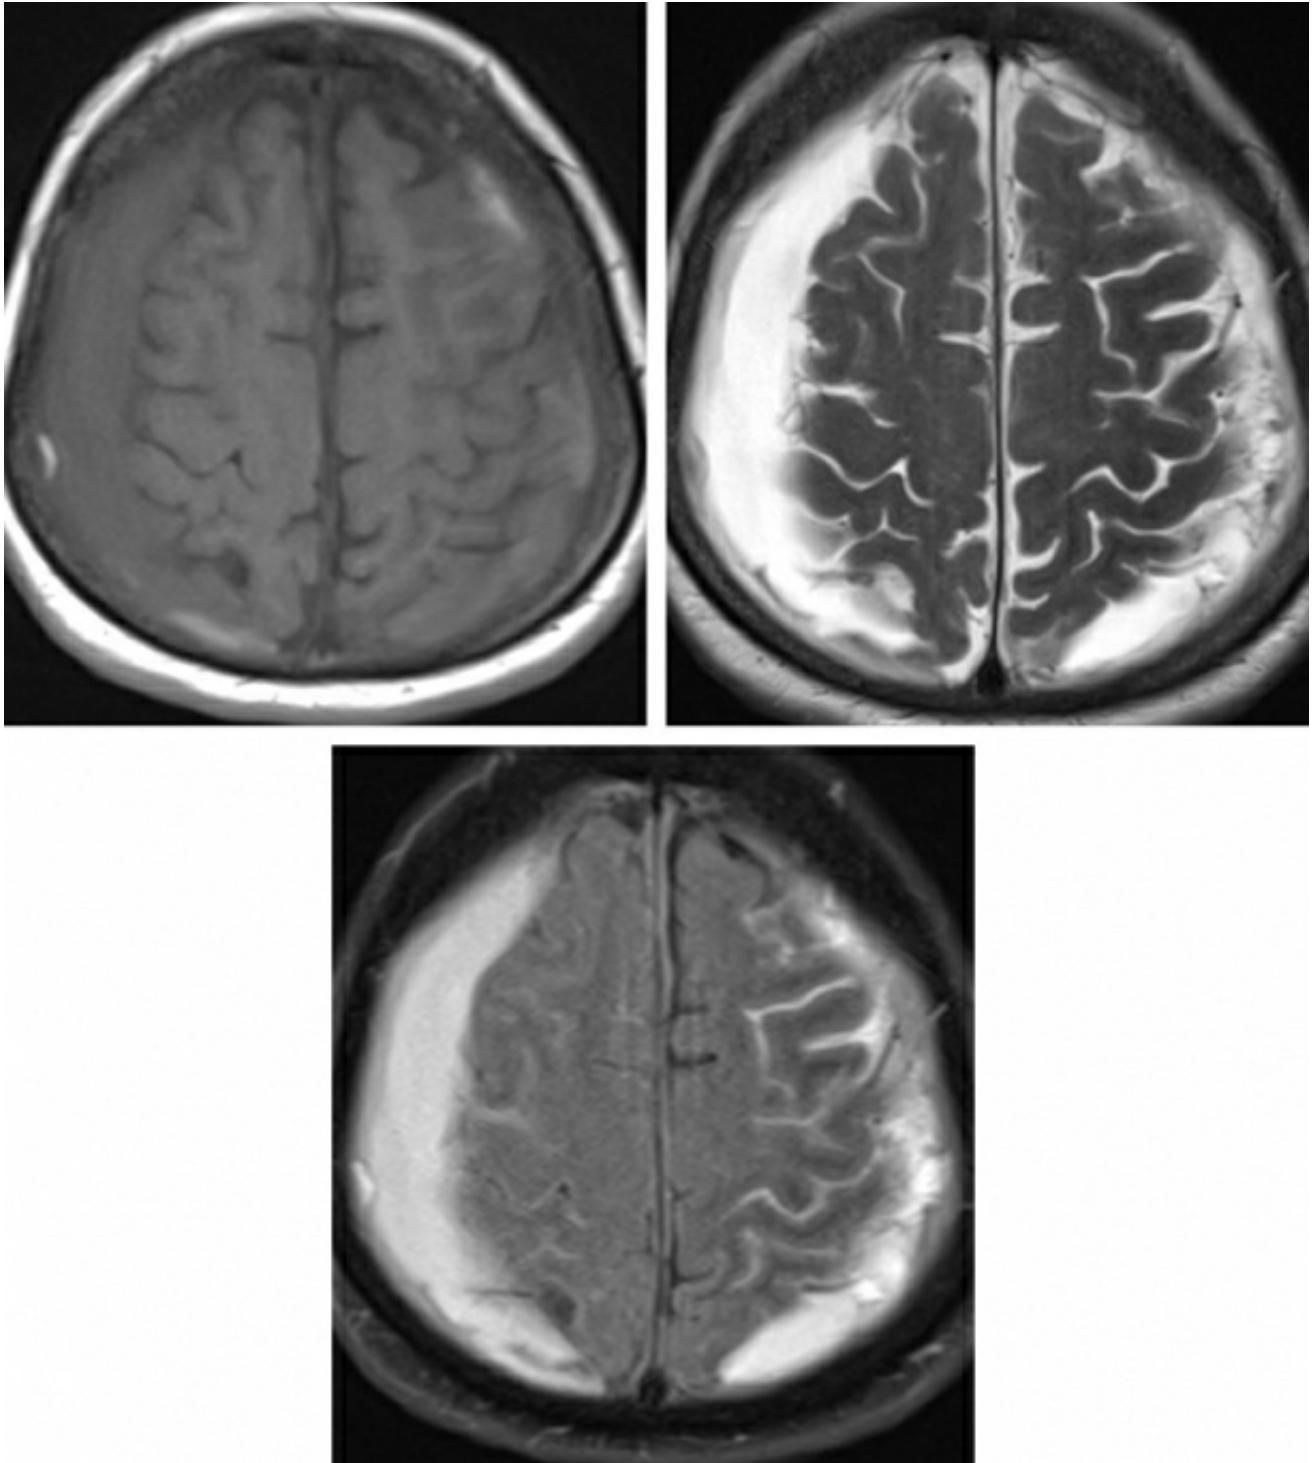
These subacute subdural hematomas are intermediate to bright in signal intensity on T1 (top row left) and hyperintense on both T2 (top row right) and FLAIR (bottom row). CSF
